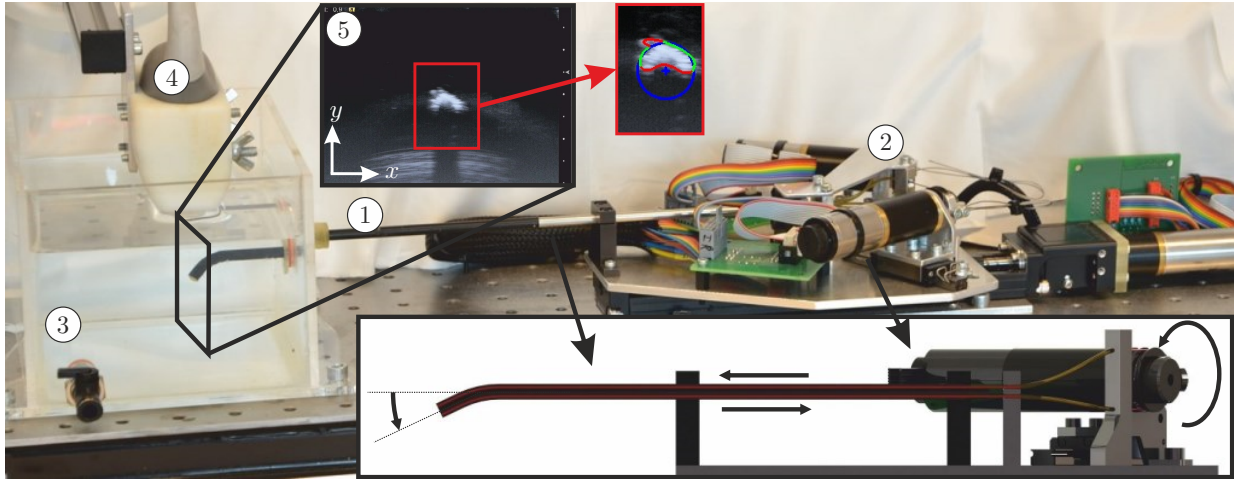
The experimental setup used to control the robotically-actuated delivery sheath (RADS). ① Actuated delivery sheath. ② Motors and accompanying electronics used to control the articulating tip of the RADS. The inset depicts a longitudinal cross-section of the RADS. An antagonistic configuration of a pair of tension wires (red) is actuated by a pulley-driven system. Each pair of tension wires (total of two pairs) is guided through the flexible shaft and through two incompressible tubes (yellow) to actuate a single degree-of-freedom of the articulating tip. ③ Container filled with water. ④ Ultrasound transducer. ⑤ Ultrasound image with a radial cross-sectional view of the RADS (Fig. 3).
